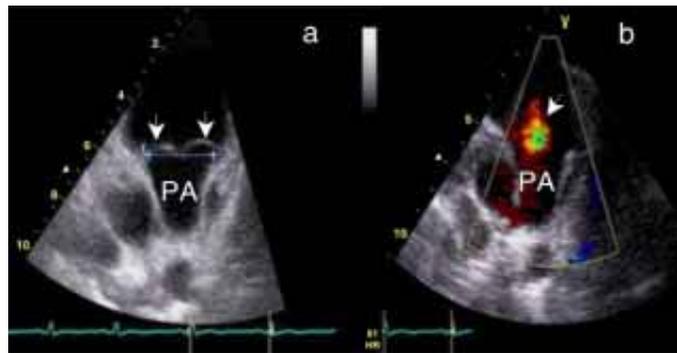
(a) Two-dimensional parasternal short axis image shows bulging of the pulmonary leaflets toward the right ventricular outlet (head arrows). (b) With color Doppler pulmonary regurgitation is evident (arrow). PA= Pulmonary artery.
